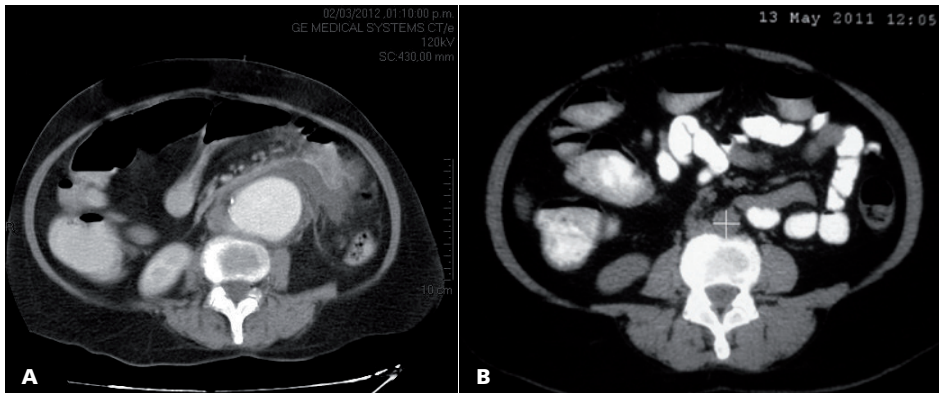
A. CT image of the infrarenal aortic aneurysm associated with perianeurysmal collection at the moment of introduction. B. CT scan of the same patient, ten months earlier, in which no aneurysmal formation is observed.
